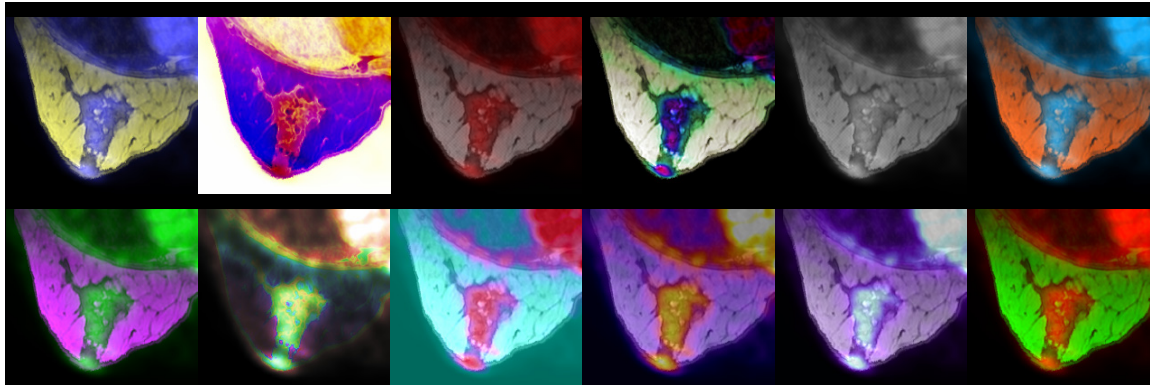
An assortment of fused images created by fusing the original MRI and PET image shown at the top of the figure. All images were created using fusion plug-ins supplied with Fusion Viewer.
